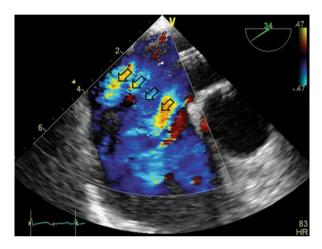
A transesophageal echocardiogram demonstrating a multifenestrated atrial septal defect with four openings (*arrows*)
